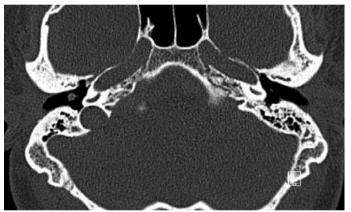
CT findings (axial view)
